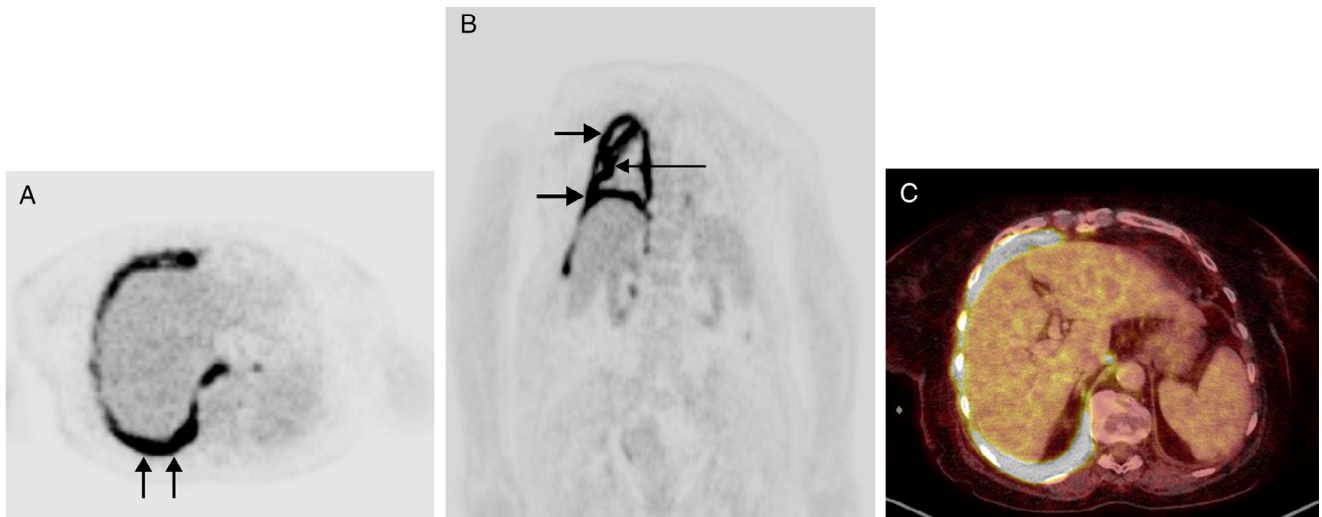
(A) PET axial image of the chest revealing hypermetabolic circumferential thickening of the pleural surface of the right hemithorax. Note the increased thickening of the posterior pleural surface (arrows). (B) PET coronal image revealing hypermetabolic thickening of the pleural surface of the right hemithorax (short arrows). Note also the intense FDG uptake by the oblique fissure (long arrow). (C) PET-CT fusion axial image showing marked hypermetabolic thickening of the pleural surface of the right hemithorax at the level of the posterior costophrenic angle. On the basis of these images, this region was selected for biopsy.
